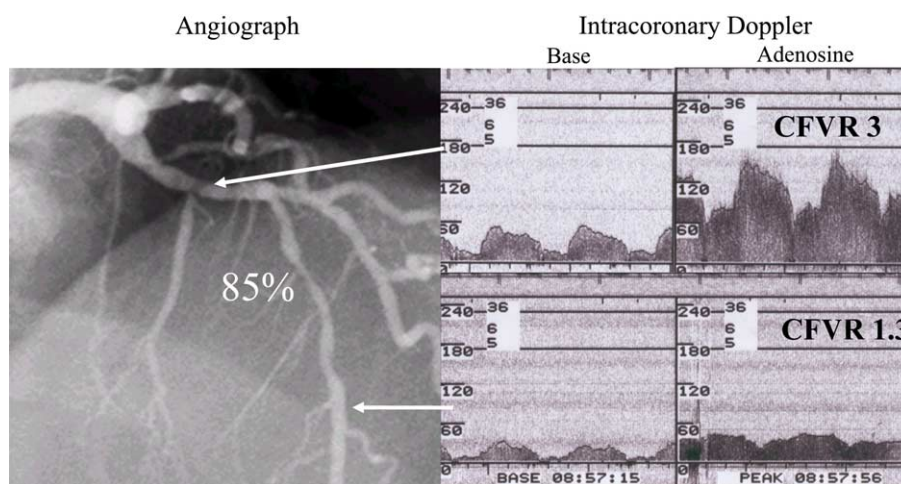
The importance of measuring CFVR distal to the stenosis. Before the stenosis CFVR measured by intracoronary Doppler ultrasound is normal (upper panels) whereas distal to the stenosis it is significantly reduced (lower panels).
